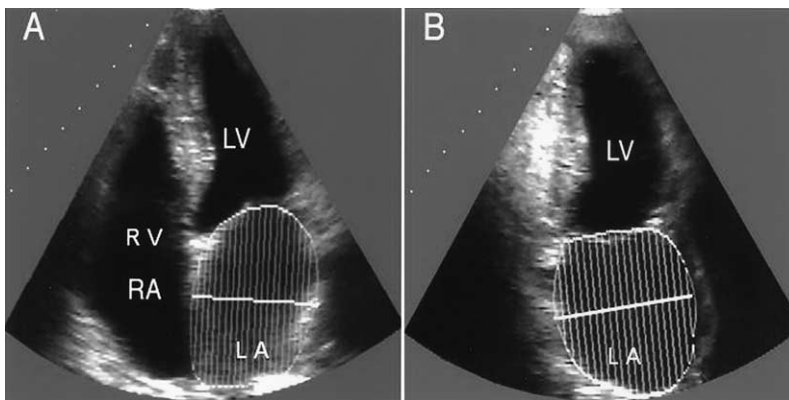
Assessment of LA volume by transthoracic echocardiography using the disk method. Two-dimensional echocardiographic images of the apical 4- (A) and 2-chamber (B) views are shown. The left atrial endocardium (LA) was digitally traced, and LA volume was computed using the TomTec workstation software by placing 21 equidistant disks perpendicular to the short axis of the left atrium. LV = left ventricle; RV = right ventricle; RA = right atrium.
